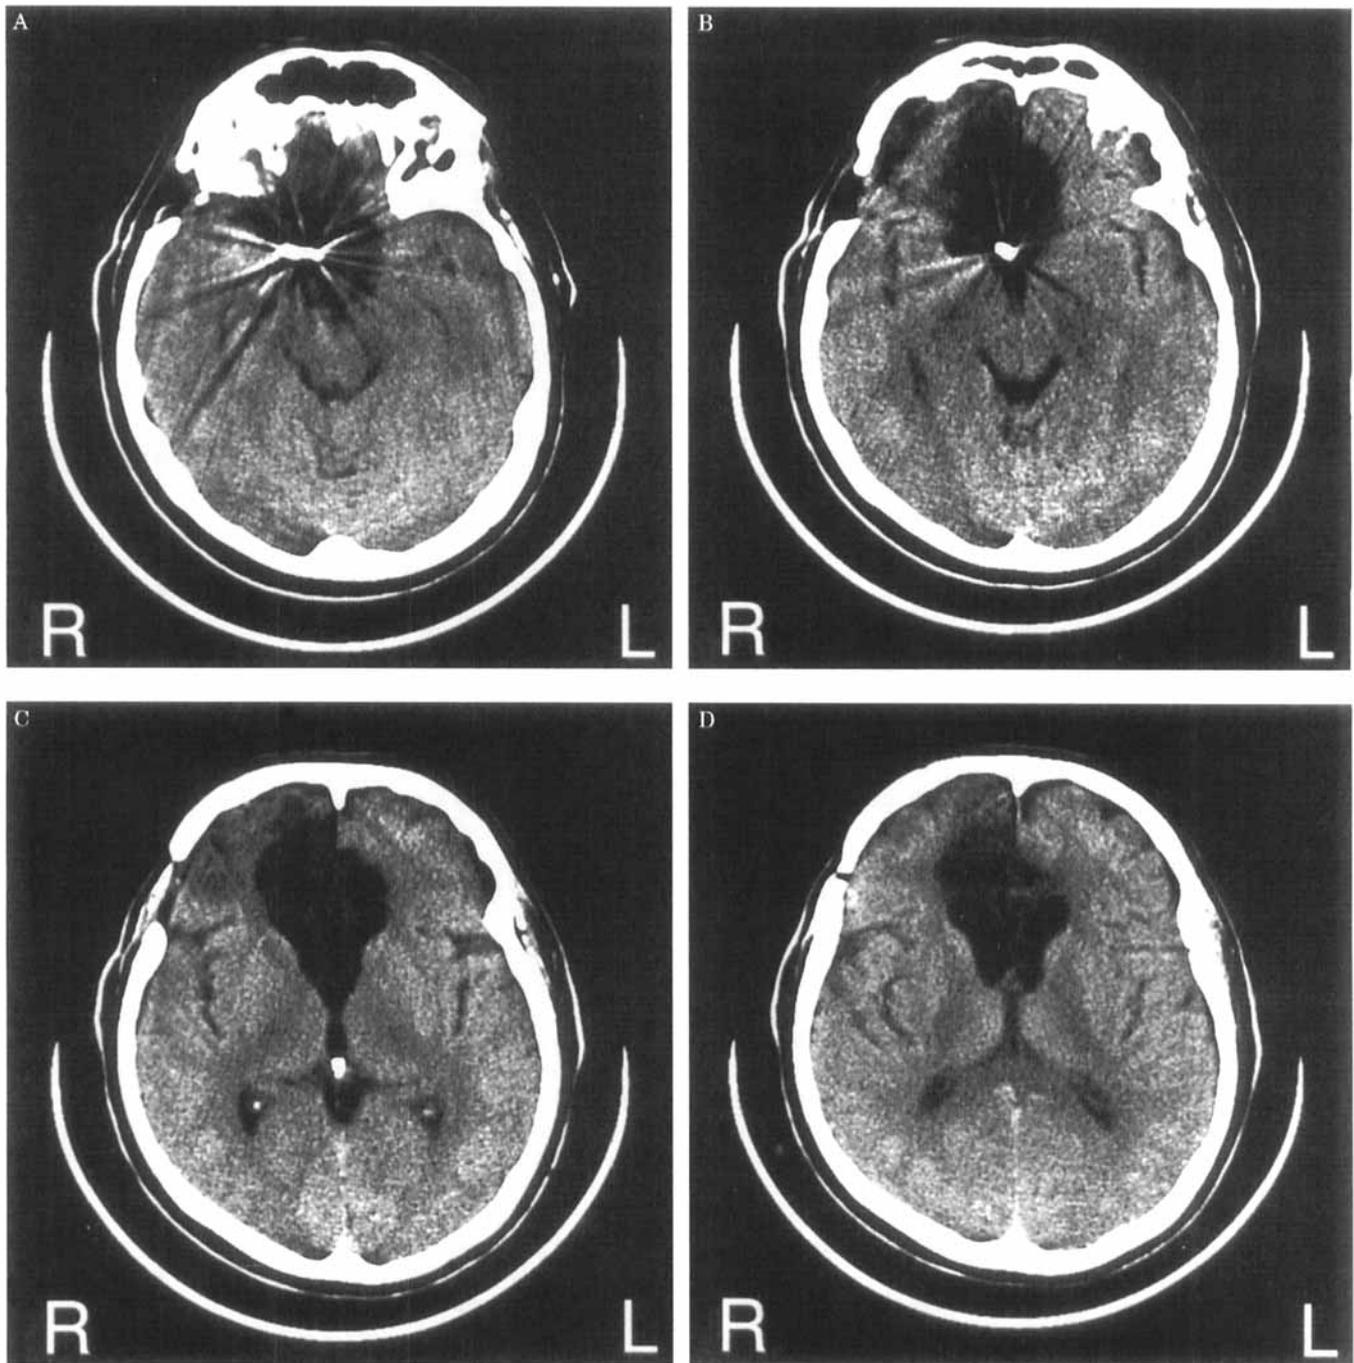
Axial CT demonstrates bilateral damage to the basal forebrain/septal region, anterior cingulate gyrus, and prefrontal cortex. Prefrontal involvement is more extensive on the right side.
